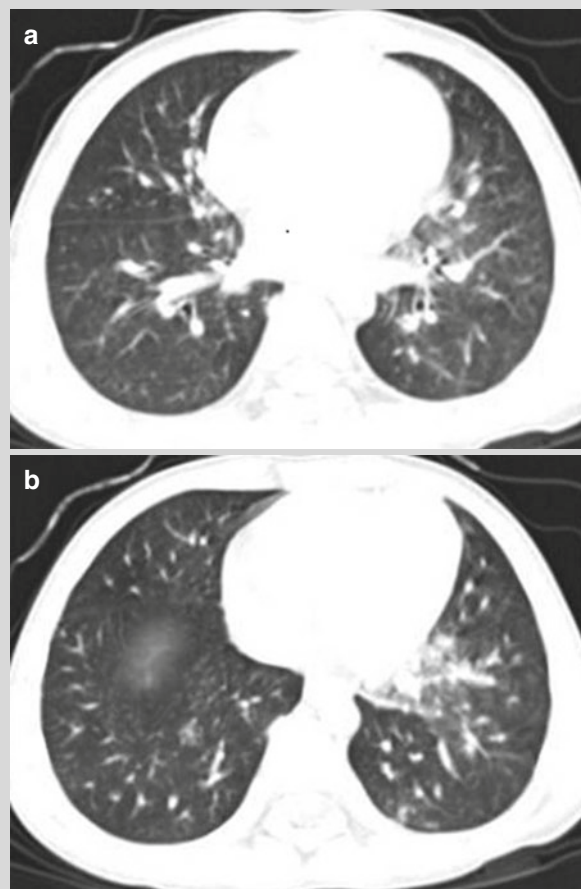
(a, b) Chest CT scan revealed rare poorly defined ground glass opacity in bilateral lower lung lobes, which was predominantly in the left lower lung lobe
